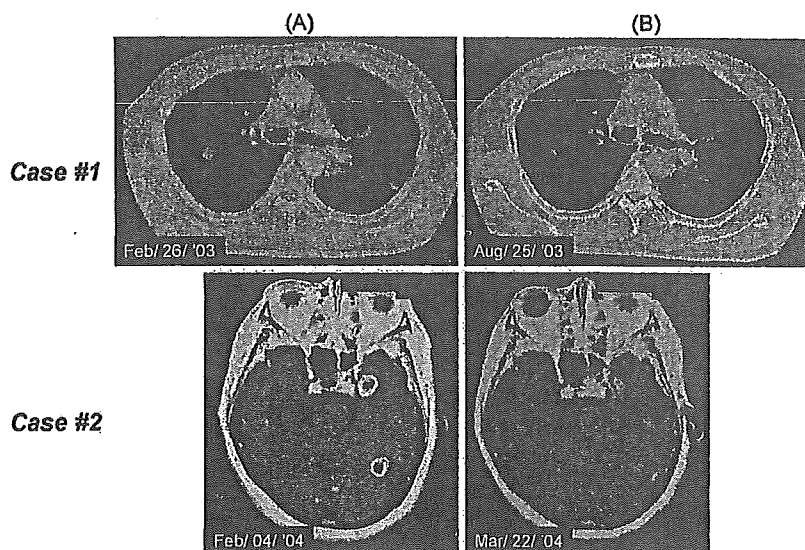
Clinical case #1*: a 63-year-old man with adenocarcinoma of lung. CT scan before treatment (A) and after initiation of EKB-569 (B). *Clinical case #2*: a 49-year-old woman with adenocarcinoma of brain metastasis. MRI scan before treatment (A) and after initiation of EKB-569 (B).
